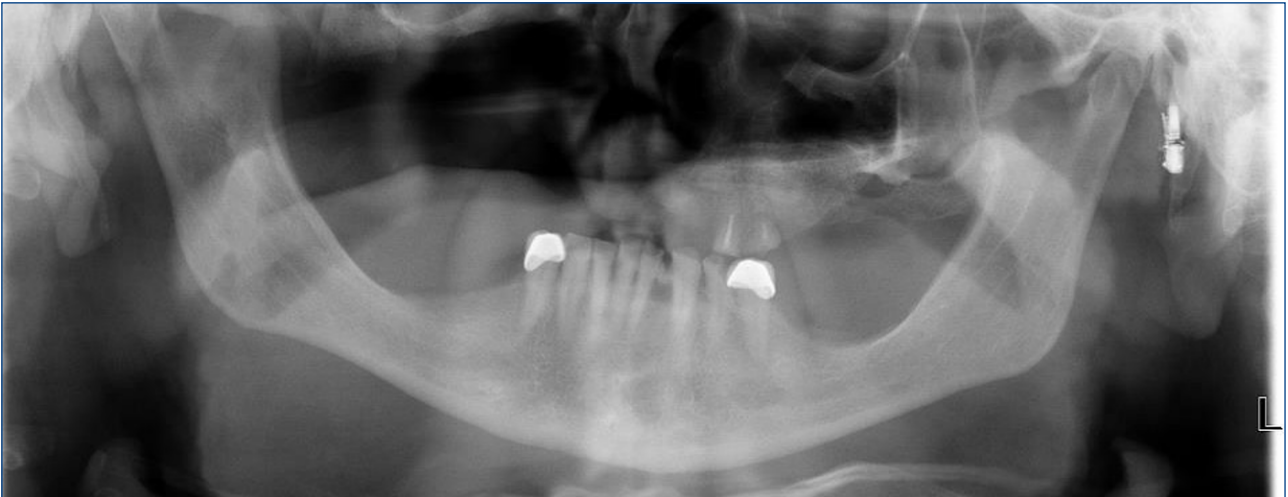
Preoperative panoramic radiograph of the patient (2023)
